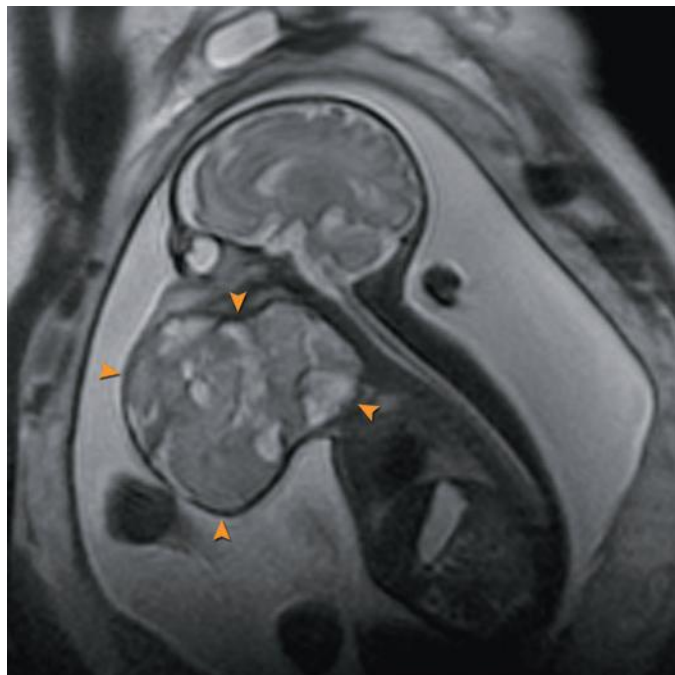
Large oropharyngeal teratoma at 32 weeks' gestation. Sagittal T2-weighted imaging demonstrates a mixed cystic and solid mass (arrowheads) involving the mandible, maxilla, and oropharynx with airway obstruction, necessitating an EXIT (ex utero intrapartum treatment) procedure at delivery.
